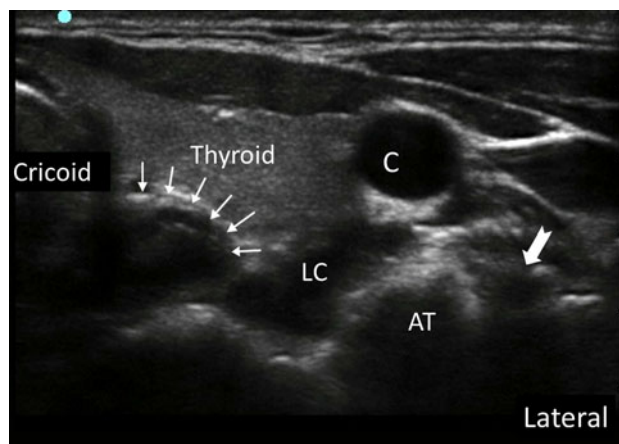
Ultrasound image of the neck at the C6 level on the left side showing the esophagus (line arrows) and nerve root (bold arrow)
